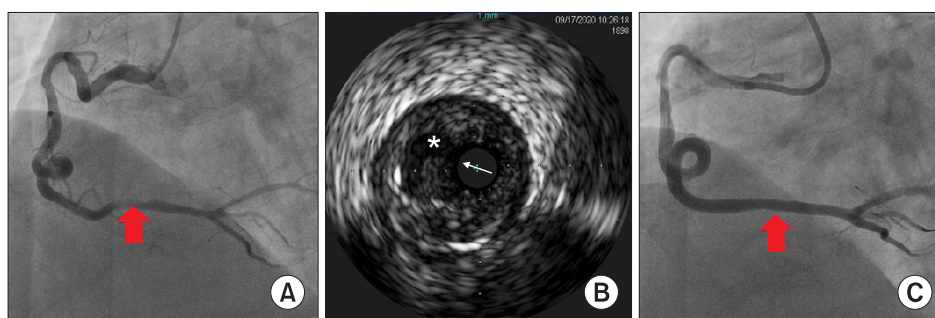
(A) Follow-up angiogram showed resolved thrombi in ostial and middle RCA, except for distal RCA (arrow). (B) Intravascular ultrasound showed plaque rupture (asterisk) in distal RCA with MLA of 2.6 mm² and plaque burden of 87%. (C) Zotarolimus-eluting stent (Resolute OnyxTM, 3.5×38 mm; Medtronic) (arrow) was implanted, resulting in good antegrade flow without residual stenosis. RCA: right coronary artery, MLA: minimum lumen area.
